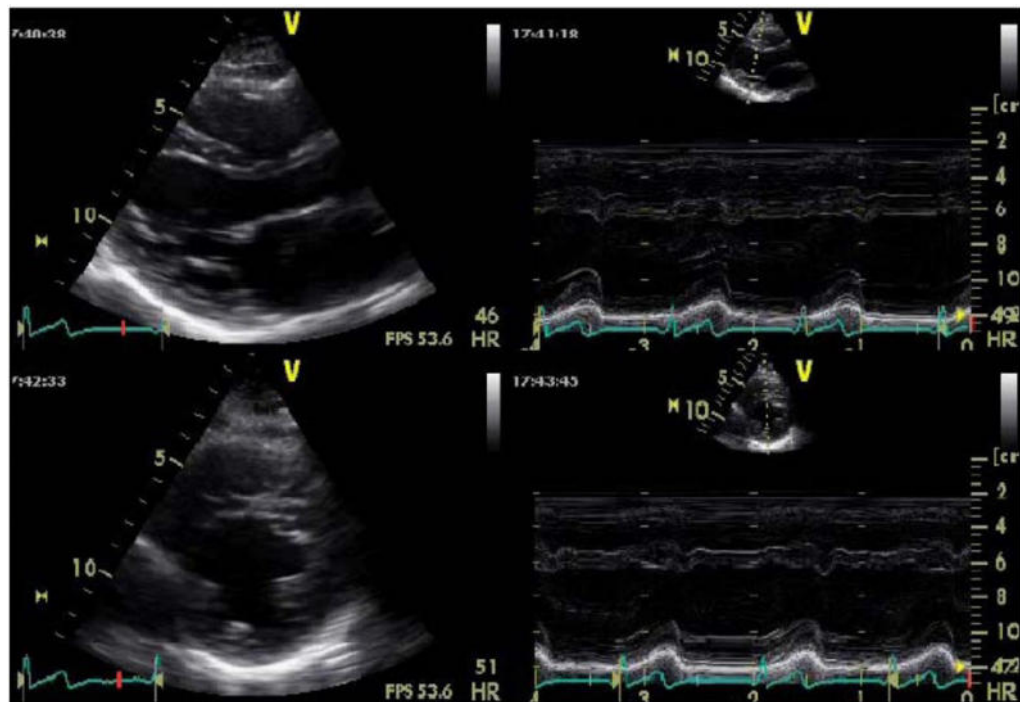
Representative images of M-mode from the parasternal long-axis view (upper panels) and short axis view (bottom panels). From Daly, Abbasi and Kwong[26].
